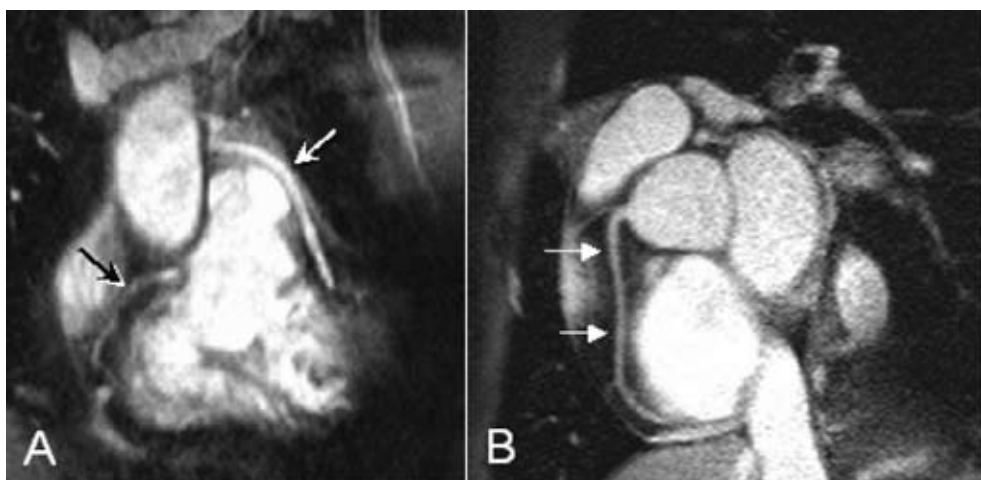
Non-invasive coronary angiography with MRI. In Panel A, a native right coronary artery (black arrow) and a venous coronary bypass (white arrow) on the left anterior descending coronary artery can be observed. In contrast, Panel B depicts the right coronary artery (white arrows) of a healthy volunteer. Images were acquired with a 1.5 T system, using T_2 -preparation for background suppression during respiratory gating.
